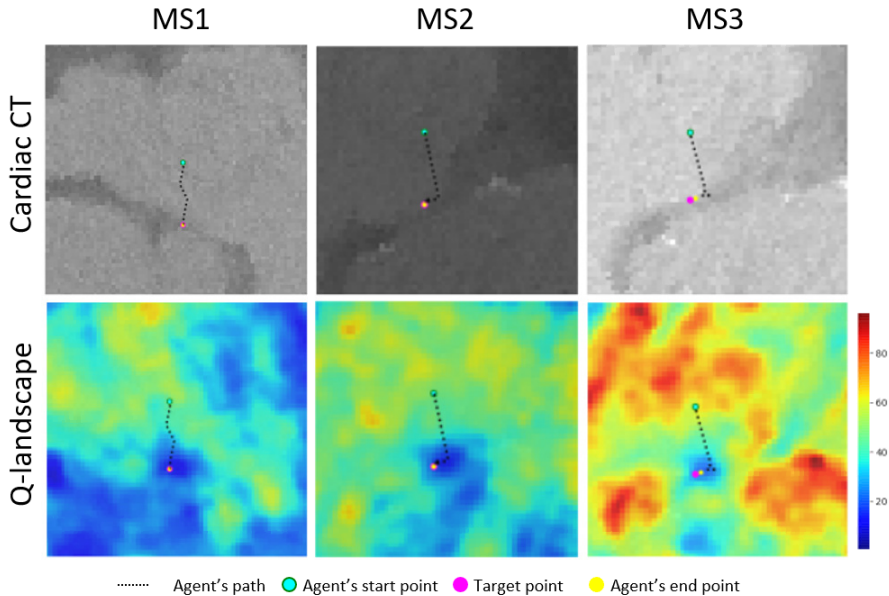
The agent’s path in the cardiac CT image (top) and the q-landscape (bottom) for each of the target landmarks: MS1, MS2 and MS3. The higher q-values are depicted in red and the lower q-values in blue. It is visible that the q-values around the target landmark are lower, as mentioned in [217].
